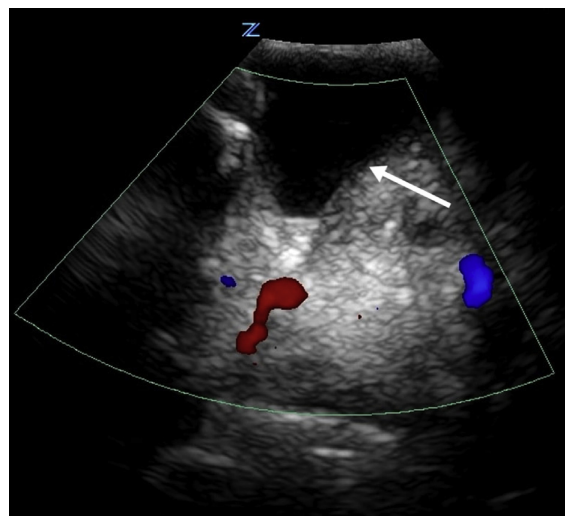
Point-of-care ultrasonography using color Doppler, demonstrating a well-circumscribed anechoic structure (arrow). Doppler did not reveal internal vascularization.
